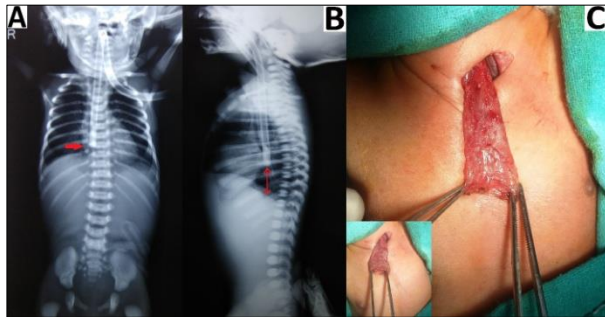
A,B) Preoperative chest radiographs (AP and lateral views; A and B) showing red rubber catheter in the esophagus arrested at the T8 vertebral level (red arrow) with absence of gas in the abdomen, C) Operative pictures (with inset image) during esophagostomy showing dilated, long, colon like upper pouch.
